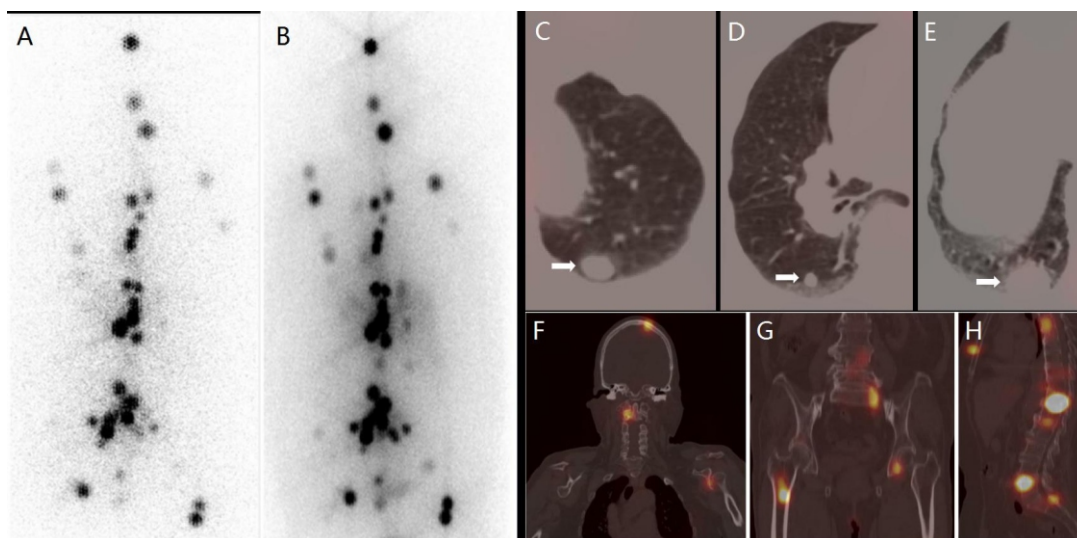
Three months later, the patient was referred for iodine-131 (^{131}I) treatment to our department. The thyroglobulin level at that time was $332.3\mu\text{g/L}$ and TSH: 42 mU/L . A diagnostic whole-body ^{131}I scan revealed multiple ^{131}I -positive lesions predominantly in the axial bone area which highly indicated bone metastases (A). A dose of 9.25GBq (250mCi) ^{131}I was given for treatment. Four days later, therapeutic whole-body scan showed multiple ^{131}I -avid lesions (B). Single photon emission tomography/CT fusion imaging confirmed that the lesions were all located in the bones (F-H), including the left frontal bone, sphenoid bone, cervical, sternum, ribs, humerus, multiple thoracic and lumbar vertebrae, pelvis and femoral bone. All bone lesions had no signs of bone destruction on CT. Surprisingly, nodules in both lungs had no uptake of ^{131}I (C-E).
